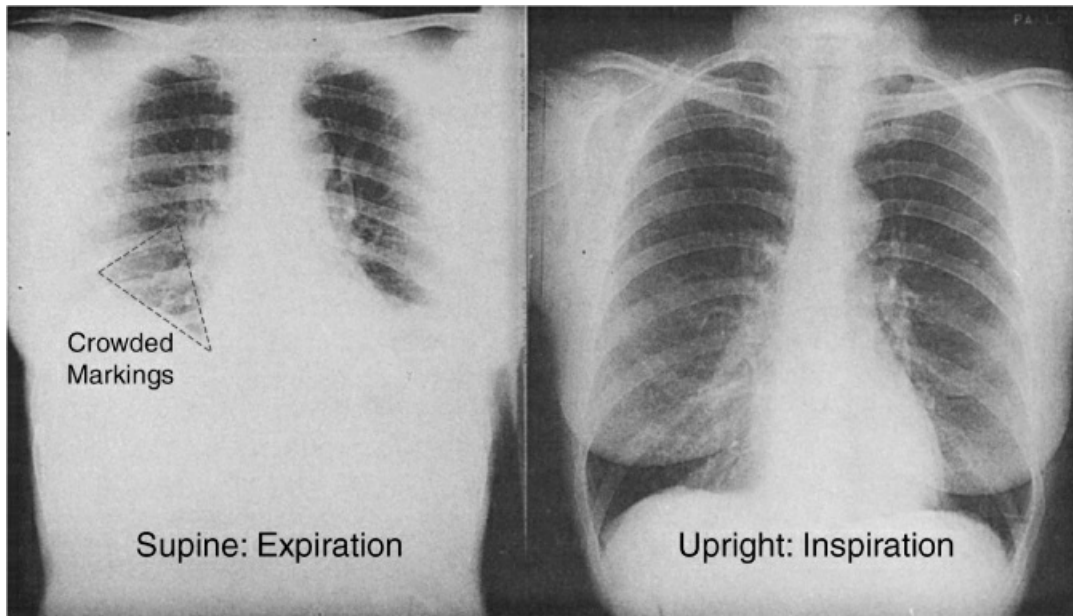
The effect of body position and lung volume on the appearance of a portable chest x-ray. Both images were obtained within minutes of each other in the same patient. The supine film taken after exhalation shows crowded lung markings at the right base that could be mistaken for a basilar pneumonia in a patient with a fever. Image on the left digitally enhanced.
